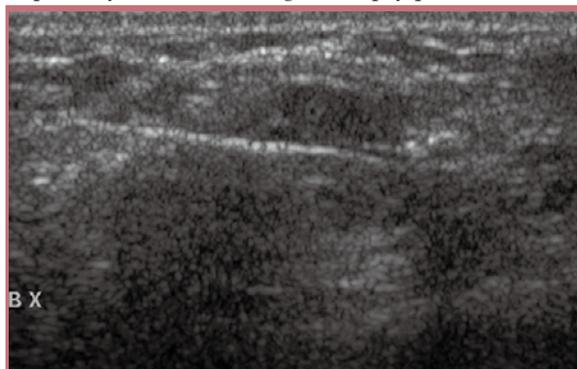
Ultrasound guided core biopsy of an ill-defined mass
